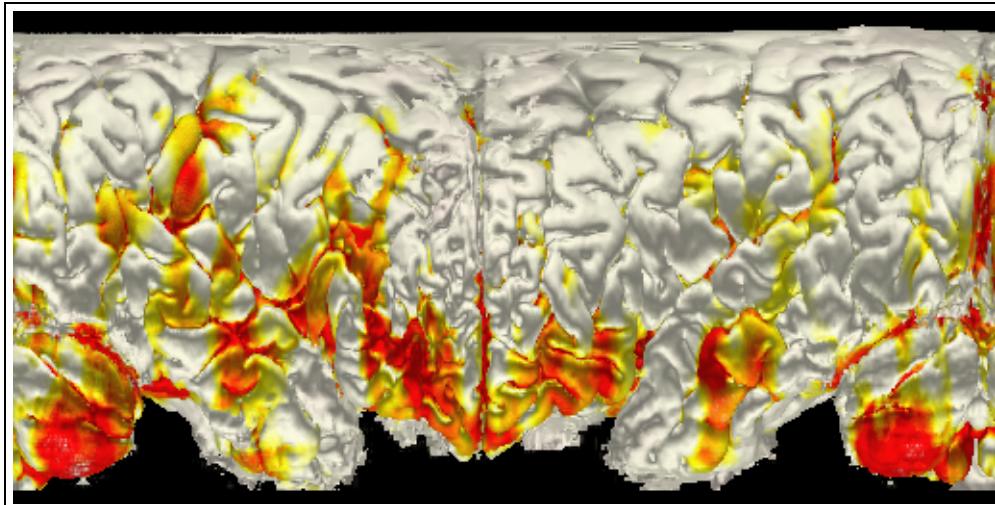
Cylinder projection (frontal view) for integrated visualization of SPECT and MRI data.
